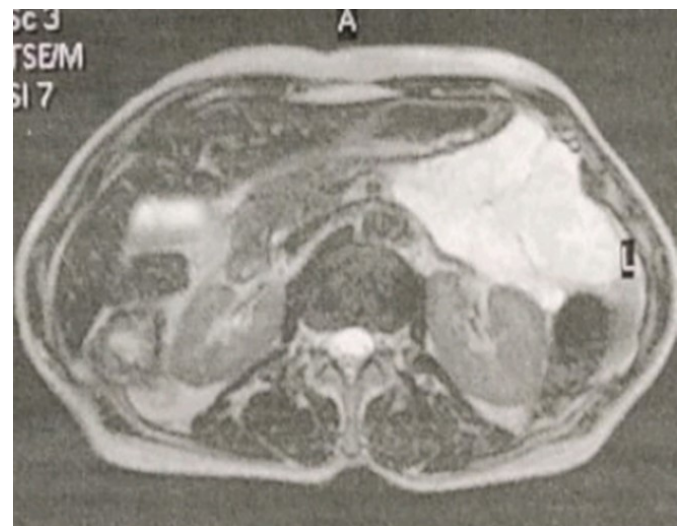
an MRI slide showing the retroperitoneal cystic mass.
